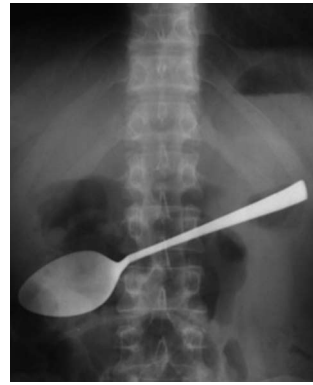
A plain radiograph of the abdomen revealing a tablespoon within the stomach.
